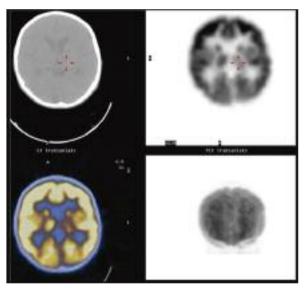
Cerebral FDG-PET study depicts decreased levels of metabolism at the left thalamus supportive of a demyelinating process.
